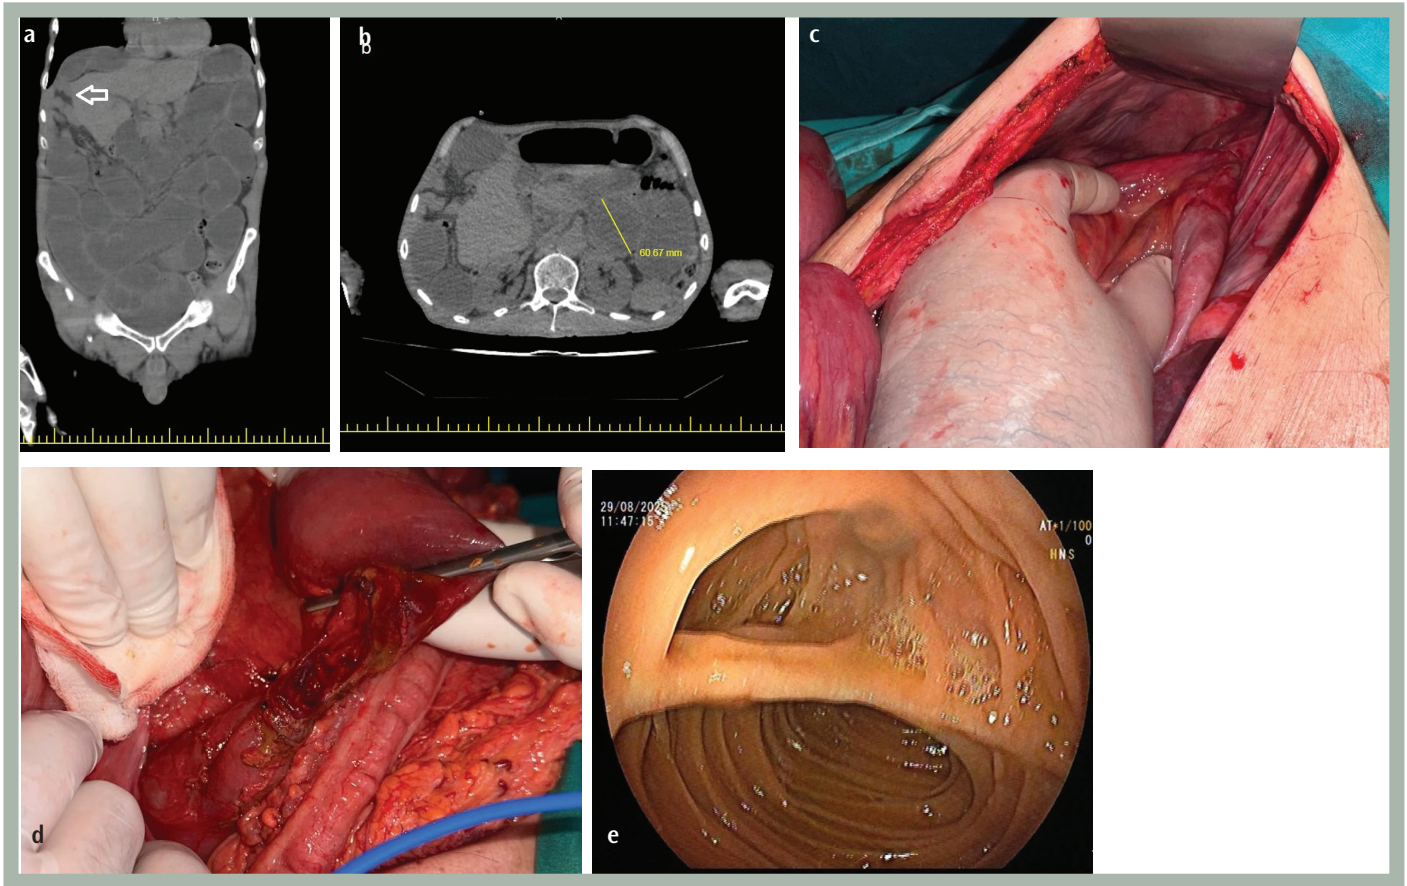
a) Coronal section computed tomography image (falciform ligament hernia defect marked with arrow), b); axial section computed tomography image (diameter of small bowel loop 60.67 mm), c); intraoperative falciform ligament hernia defect, d); intraoperative duodenum (D4) perforation image, e); postoperative endoscopic anastomosis image
